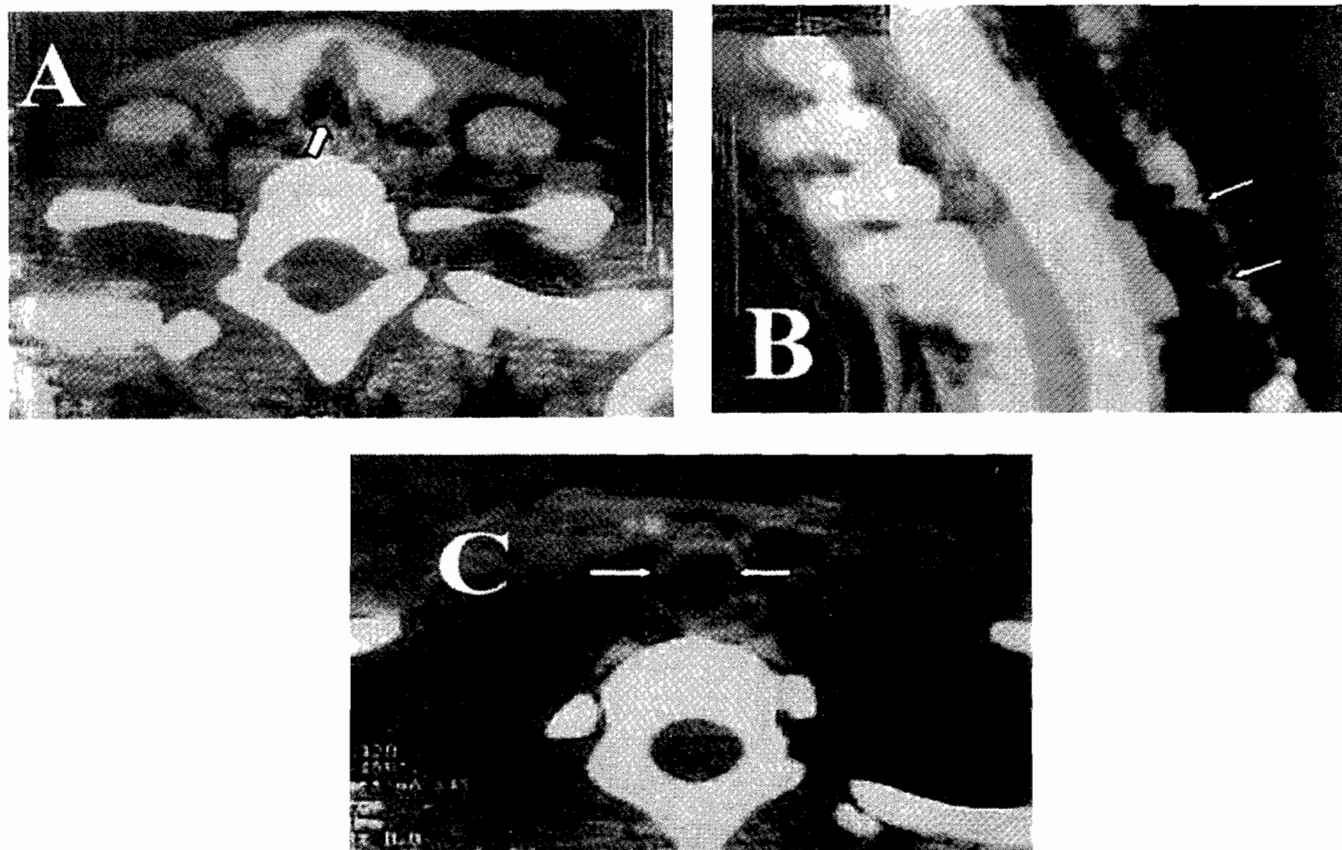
A. Plain CT scan of the neck in a 38-year old female with acquired tracheal stenosis (Case # 1) due to the development of granulation tissue (white arrow) in the tracheal. B. Reformatted CT Scan of the neck and upper chest in the same patient showing multiple tracheal stenosis due to granulation tissue (Arrow). C. Plain CT Scan of the neck in the same patient after 8 months of repeated rigid bronchoscopic dilatation of the tracheal. The tracheal size is normal (White arrows).
